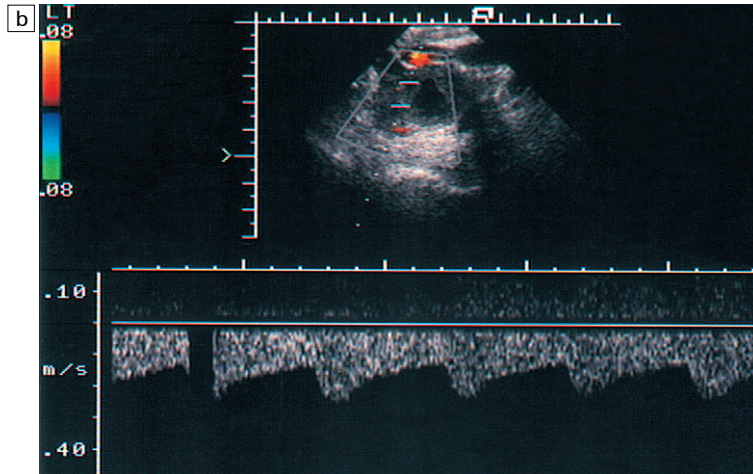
Doppler spectrum of normal uterine artery blood flow in the late follicular phase.
